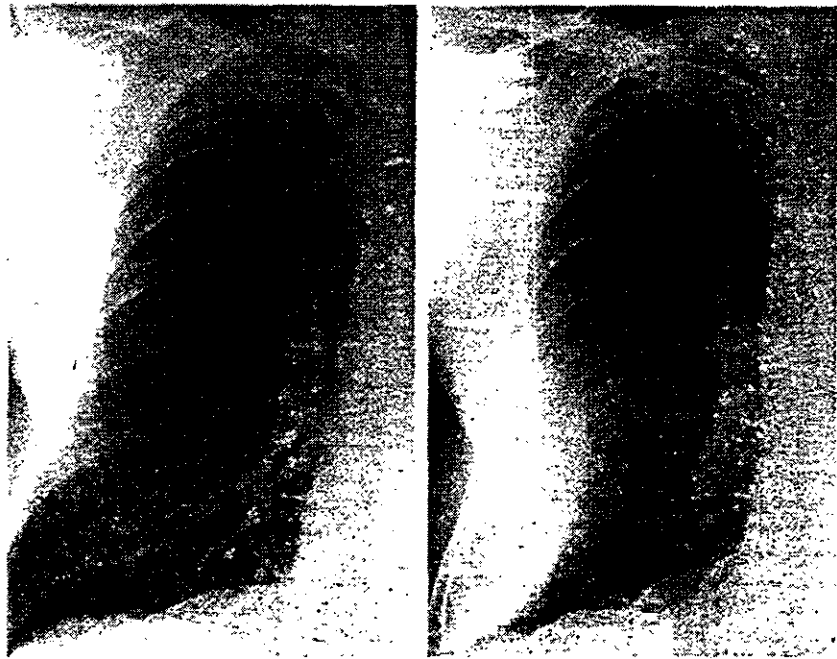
Chest roentgenograms of 51-year-old shipyard pipecoverer had been normal for 18 years (left). Three months later, pleuritic chest pain developed on right side, as well as pleural-based density (right). Exploratory thoracotomy for "mesothelioma" showed encapsulated bloody effusion. Patient has remained well for three years.
